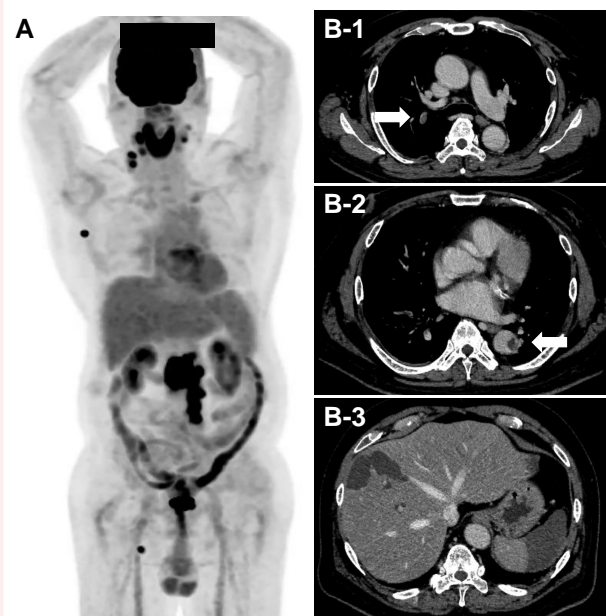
(A) The fluorodeoxyglucose-positron emission tomography computed tomography before the development of the systemic thrombosis revealed hyperaccumulation in the para-aortic, bilateral cervical, right axillary, and right inguinal lymph nodes. (B) Several days after the positron emission tomography-computed tomography, contrast-enhanced computed tomography showed multiple thrombi in the portal vein, liver artery, splenic artery, descending aorta (arrow), pulmonary artery (arrow), and bilateral popliteal veins.
